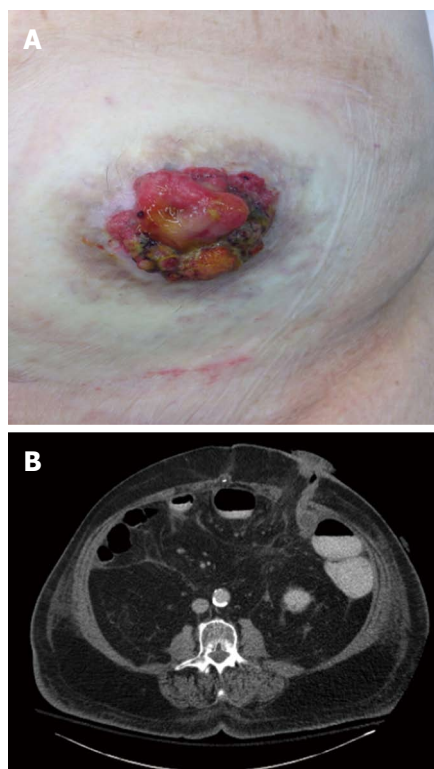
Ileostomy site on physical exam (A) and computed tomography scan (B).
